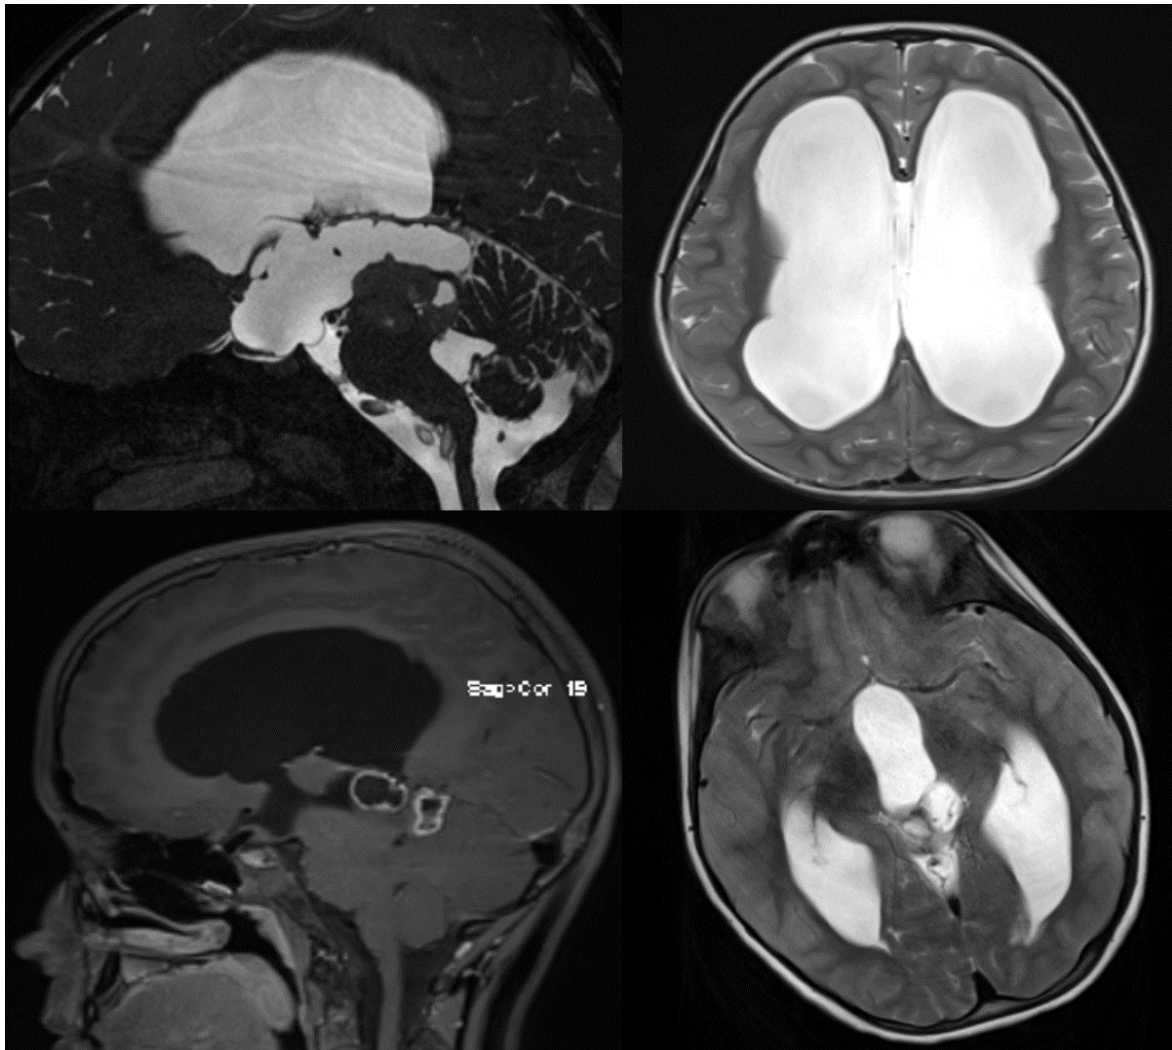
MRI images of a tectal tumor hyperintensity on T2 with hydrocephalus
